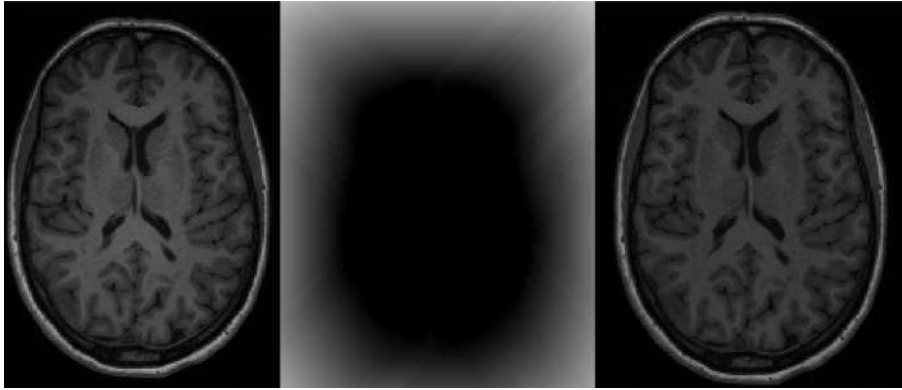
Example of bias field correction. On the left it is shown a T1-weighted image with presence of bias field (grey matter can be seen with different intensities in the left and right side of the image); the centre represents the bias field and, on the right, it is shown the same T1-weighted image corrected for the bias field.
